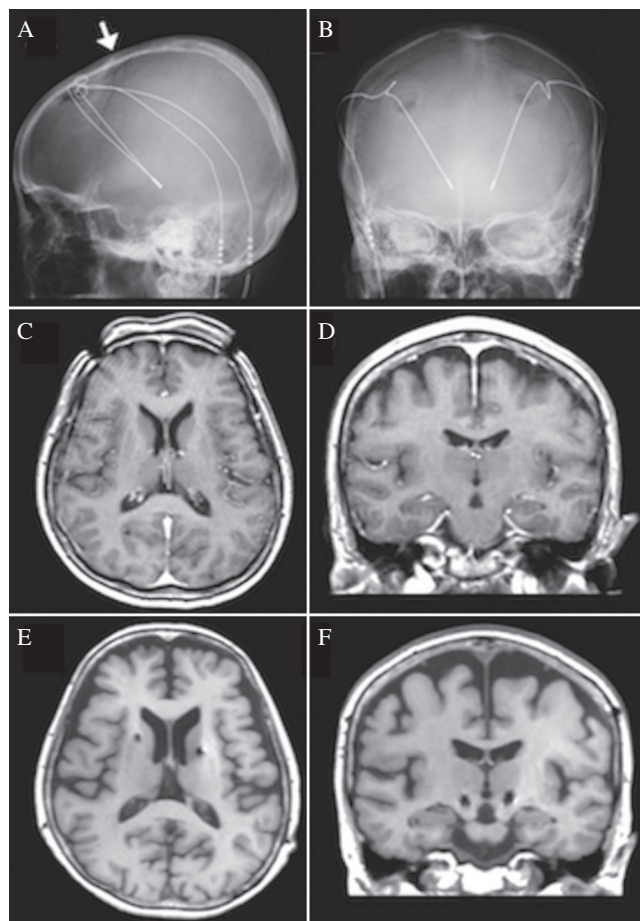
Imaging studies of the patient. A and B. Skull X-ray images showing the intracranial electrodes with the far anterior entry points. C and D. T₁-weighted images with contrast for stereotactic planning at the age of 68 years. E and F. T₁-weighted images without contrast 5 years after DBS surgery. These MRI images show the atrophic change in the brain over a period of 5 years.
